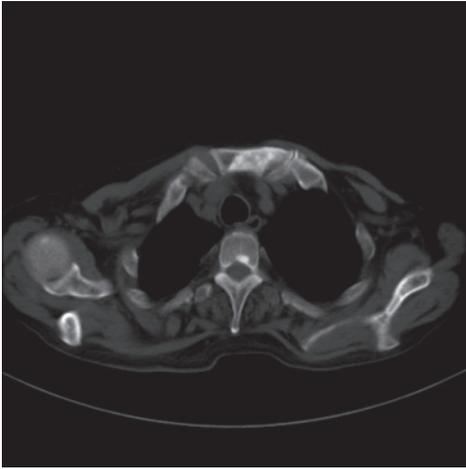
Computed tomography scan showed metastasis of sternum, thoracic vertebra and scapulae
